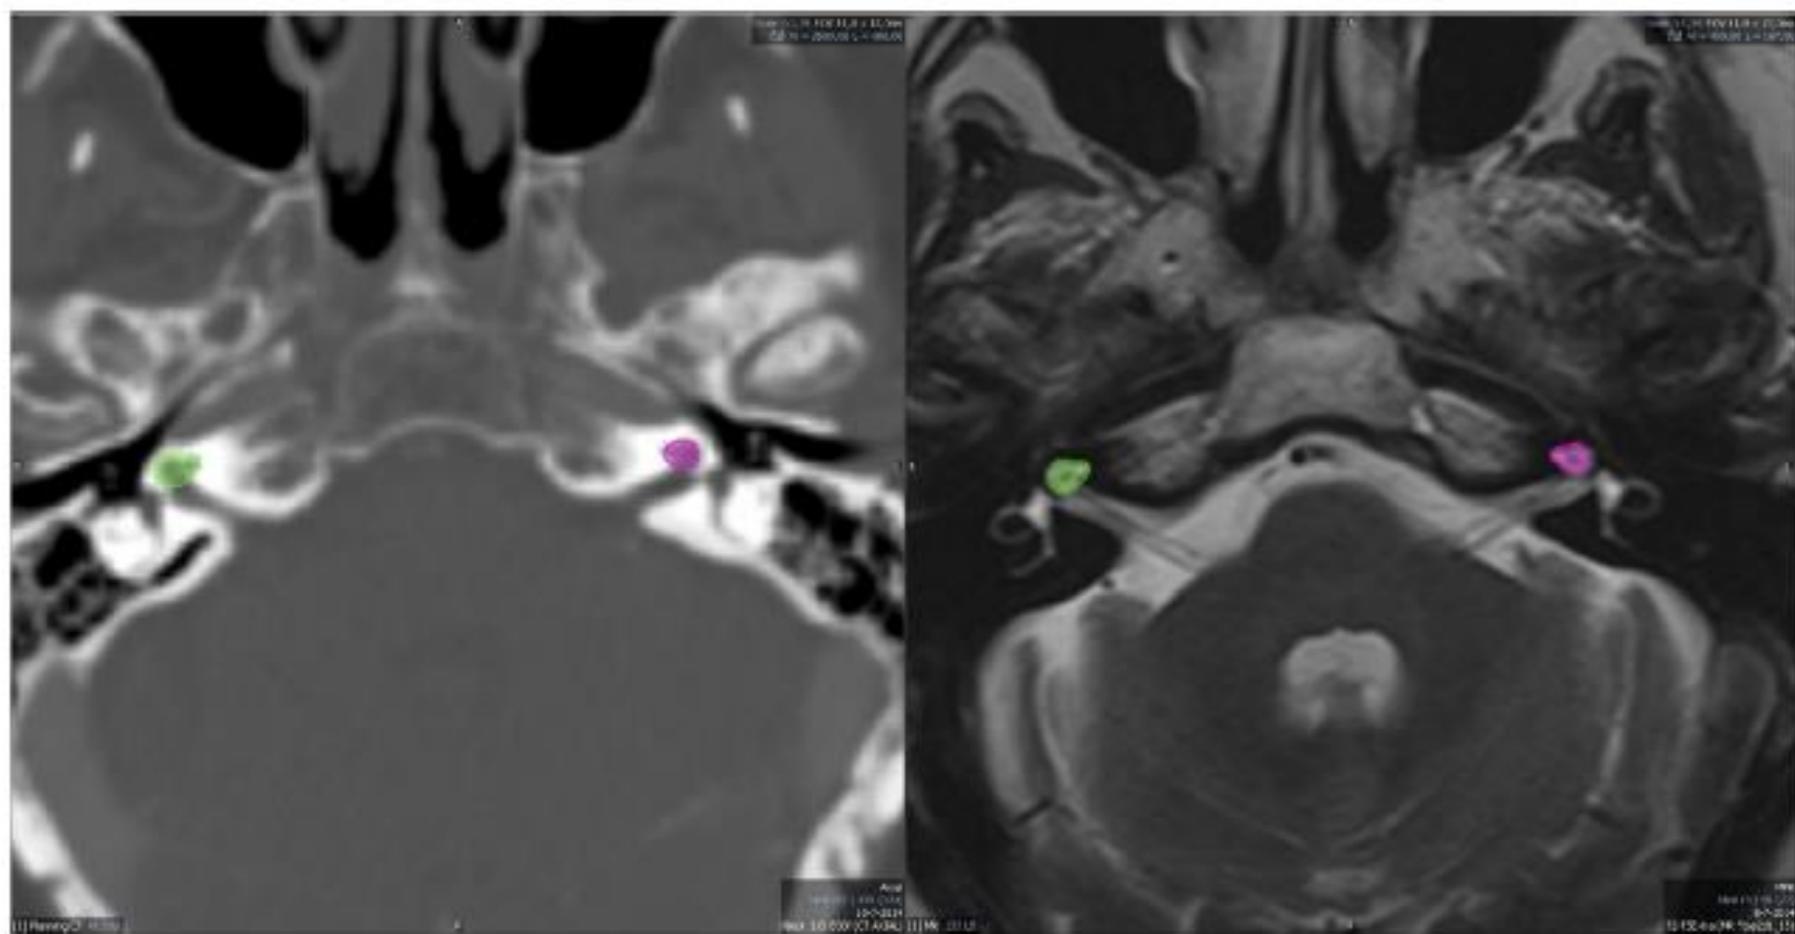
Delineation of the cochlea in CT bone settings (left), matched to MRI-T2 (right).
